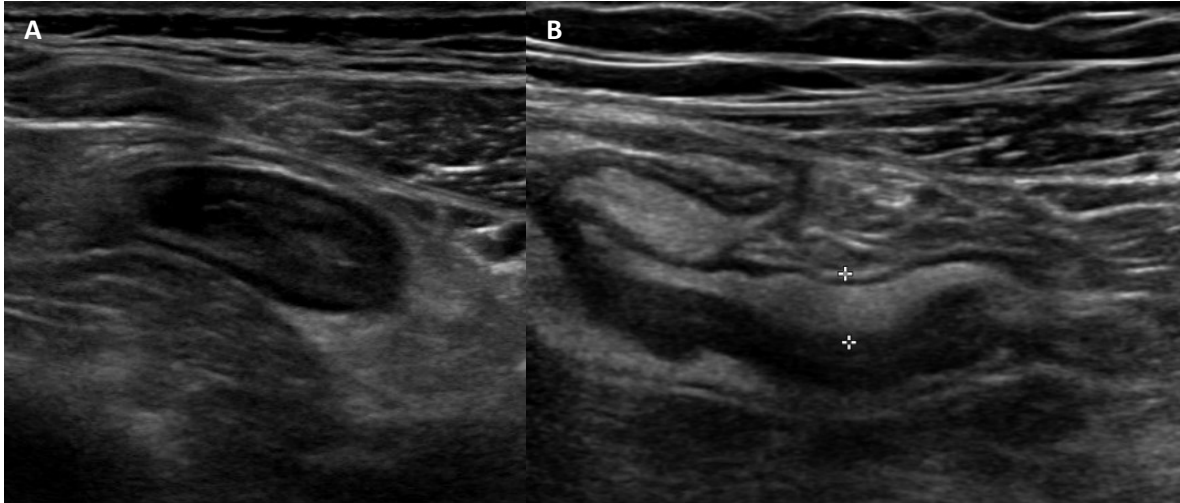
A – Bowel ultrasound, linear high-frequency probe. Thickened and edematous wall of aboral ileum, which is due to edema more hypoechoic and contours of wall layers are blurred. In the surrounding is hyperechoic swelling of fat - corresponds to active inflammation in patient with Crohn's disease.
